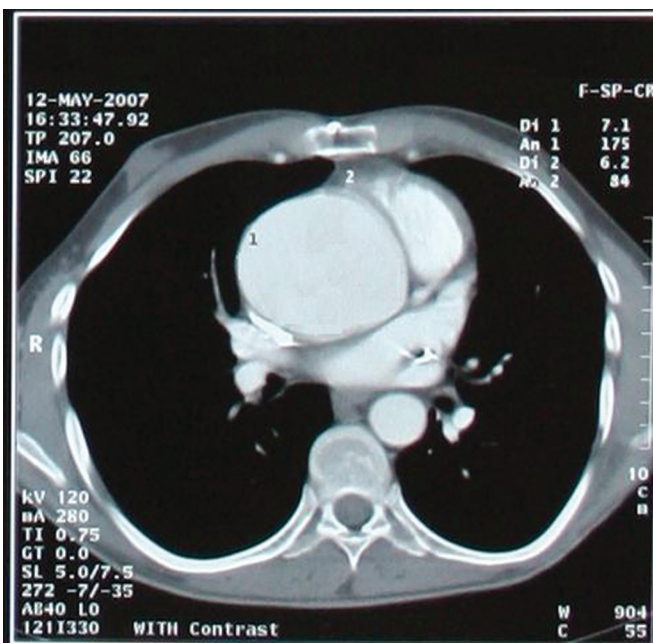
Spiral computed tomographic scan of the thoracic aorta demonstrating the A, aneurysmatic ascending aorta (diameter of 58 mm) and aorto-plasty of descending aorta and B, reoriginated left subclavicular artery.
